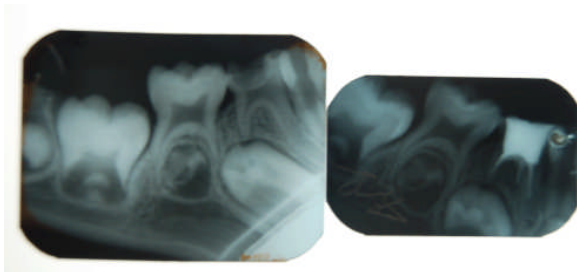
IOPA radiographs showing taurodontism of lower right first primary molar, pre and post pulpectomy.
